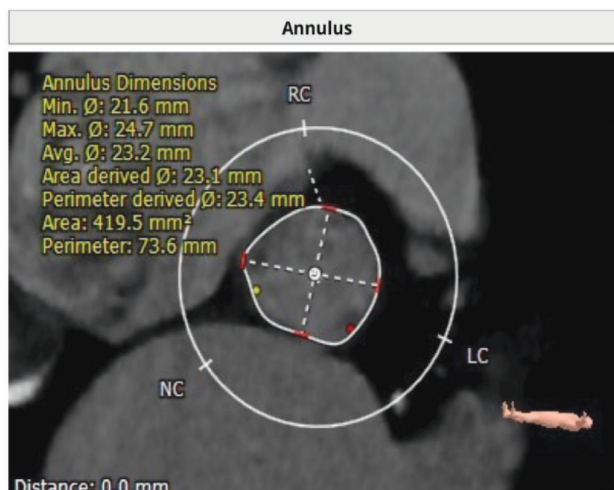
CT of the aortic valve, patient No 3
